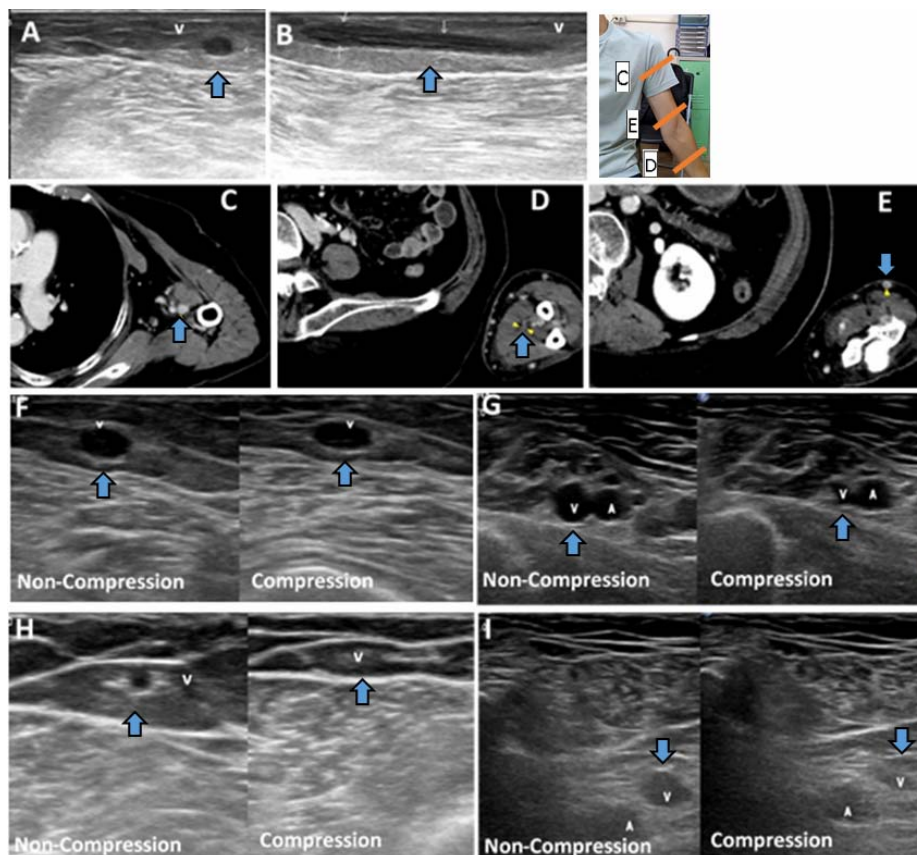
Soft tissue ultrasonography (US) on Day 1 showed thrombus in the left cephalic vein at transverse view (A). and longitudinal view (B). Computed tomography angiography of the left forearm on Day1 showed thrombosis in left axillary vein (C). ulnar vein (D). and cephalic vein (E). Soft tissue US on Day 10 showed poor compressibility in left cephalic vein (F). partial compressibility in left axillary vein (G). with good compressibility in right cephalic vein (H). and left subclavian vein (I).
